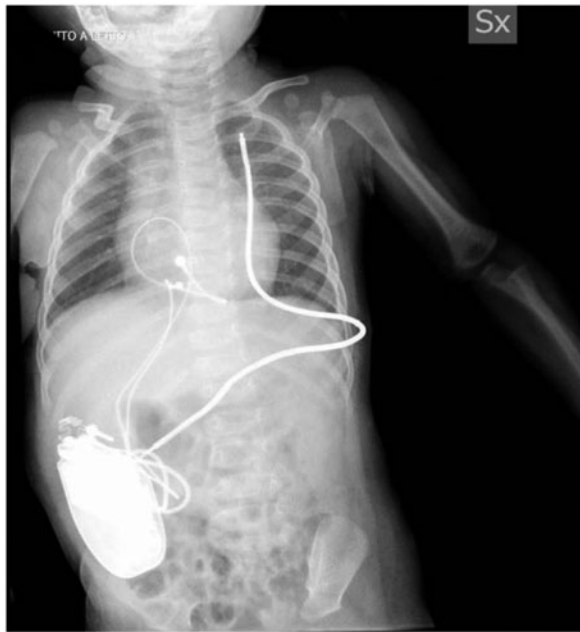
Chest X-ray (frontal projection). The implantable cardioverter-defibrillator was implanted in the abdominal pocket, the subcutaneous defibrillation coil was placed along the left chest wall and the epicardial leads were connected to the right ventricle.
